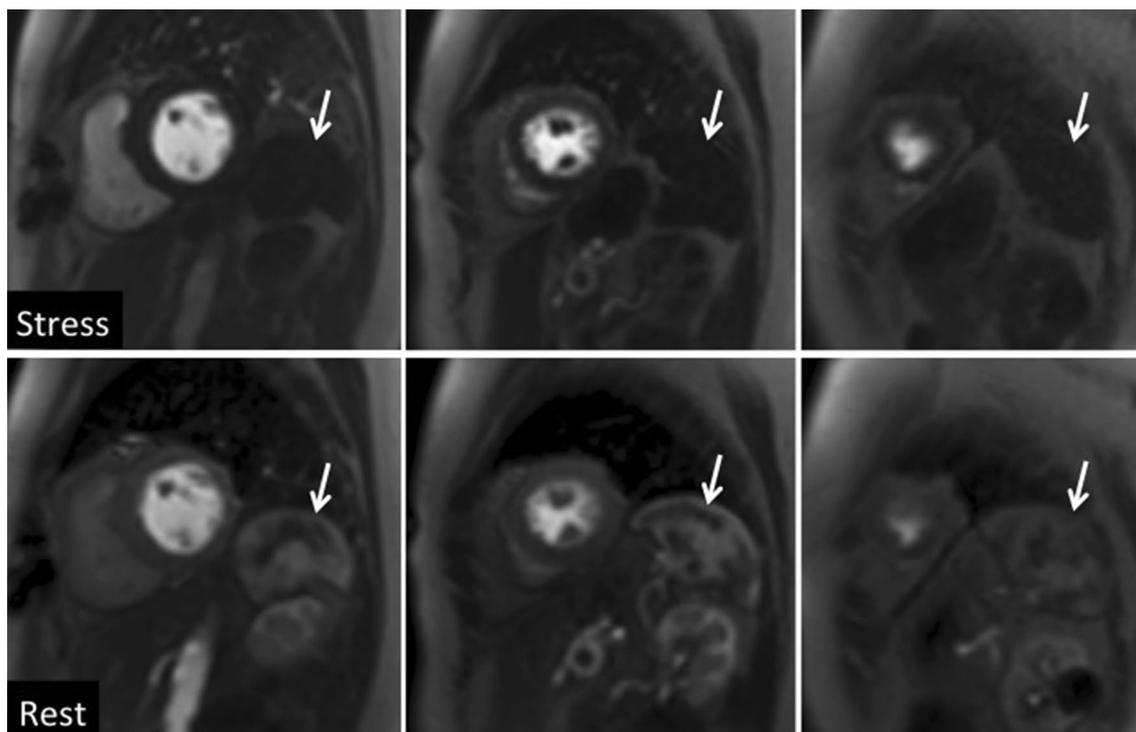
Splenic perfusion MR images in a patient undergoing stress perfusion CMR with ATP. Images obtained at stress (upper row) and rest (lower row) demonstrate the splenic switch-off phenomenon (arrows), indicating stress adequacy
